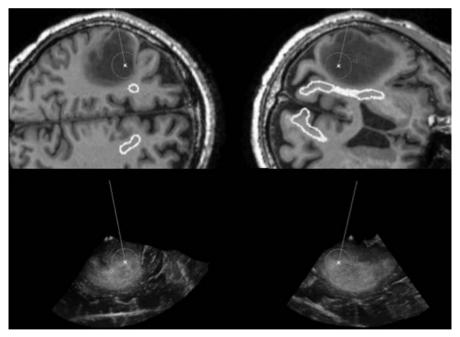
Snapshot from the navigation monitor (low grade glioma). Dual anyplane display of 3D MRI (*upper row*) and 3D US (*lower row*). The pyramidal tractography is inserted in the 3D MRI volume, and the outline of the tract is displayed as a white line. The pointer shows a considerable shift between MRI and US. The tract is outside the tumor, as shown in MRI. The position of the tumor borders can be trusted on 3D US, even though it may look as if the 3D US borders of the tumor are inside the tract on MRI
